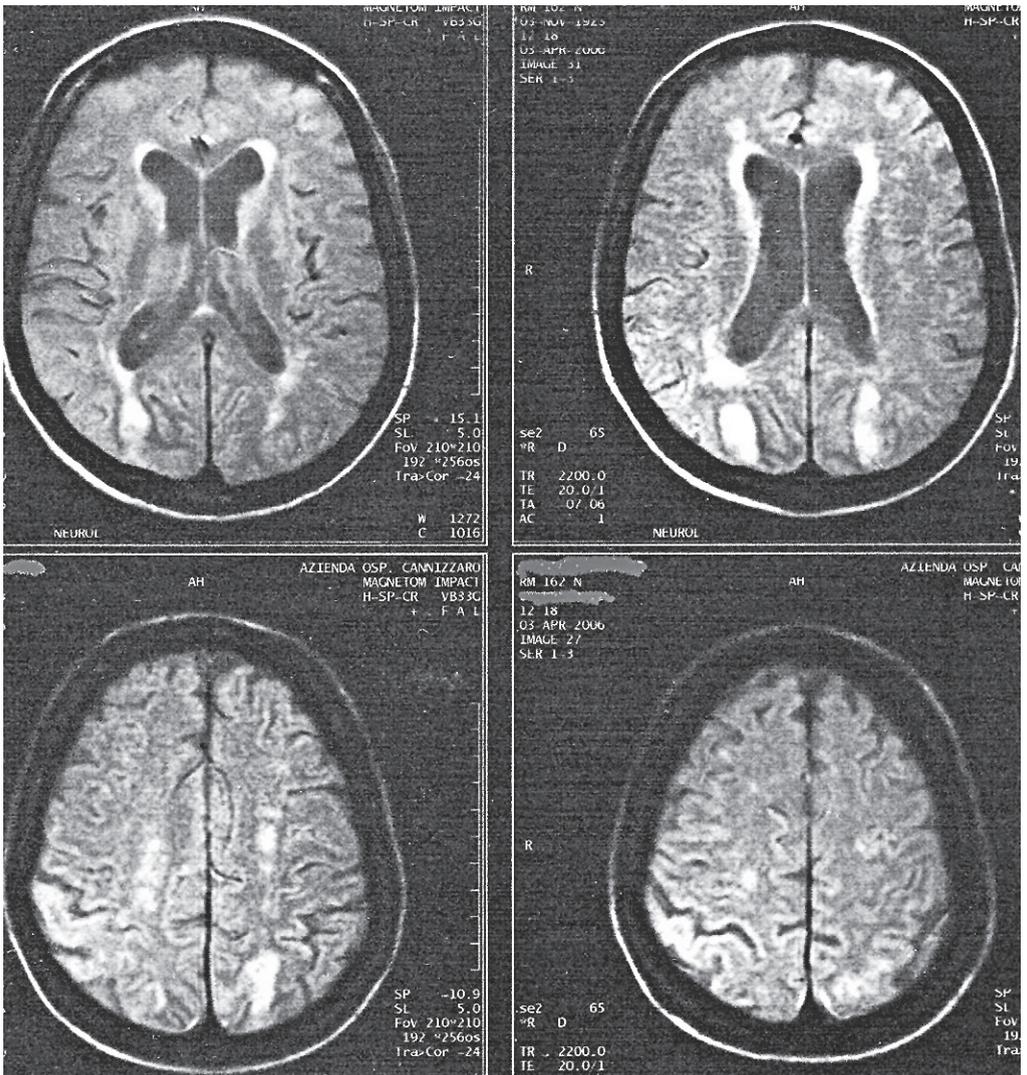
Axial T1-weighted MR scan showed cerebral infarcts in both parieto-occipital areas along the middle and posterior cerebral arteries watershed zone seen as hyperintensity foci
